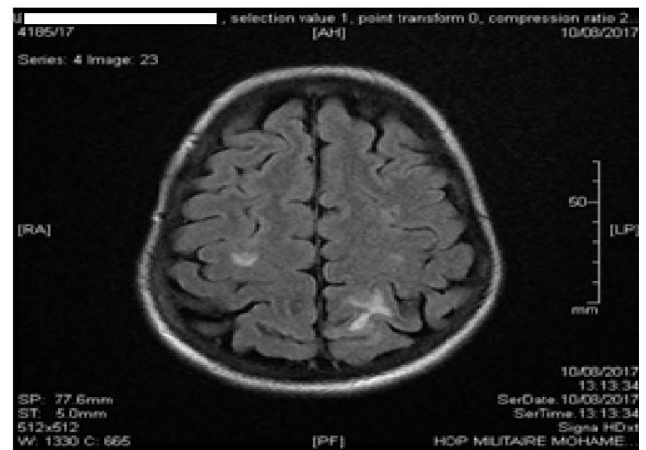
Brain MRI, axial section, FLAIR sequence: hypersignals of subcortical white matter in right frontal and left parietal areas.
